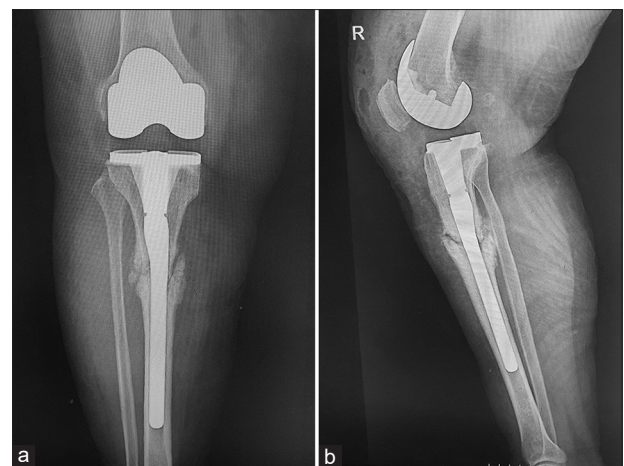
Postoperative anteroposterior (a) and lateral (b) radiographs of the acute tibial varus stress fracture treated with one-stage long-stem total knee arthroplasty, without open reduction, plating and bone graft
